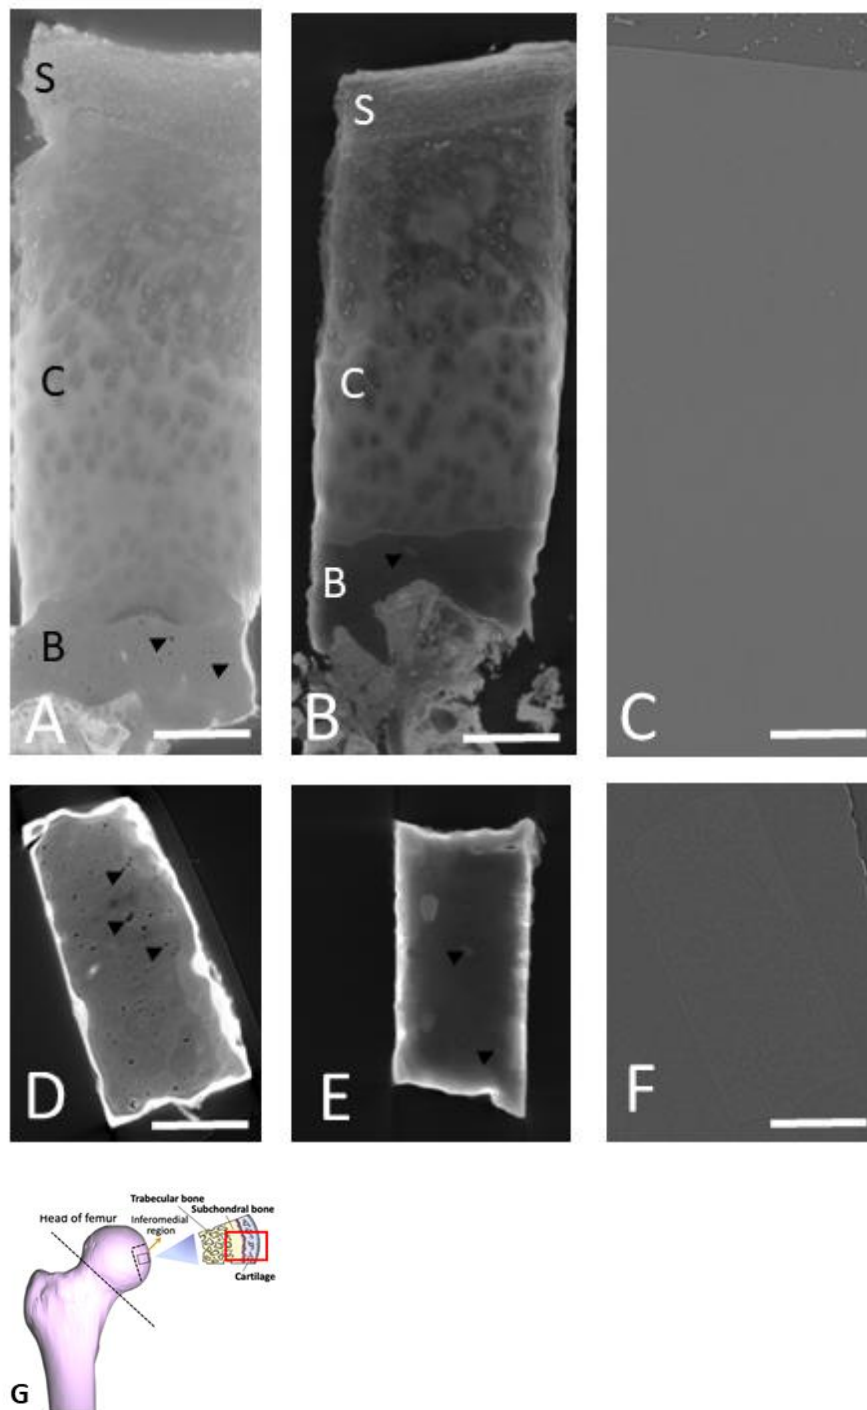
Reconstructed μ CT data of human femoral head.
